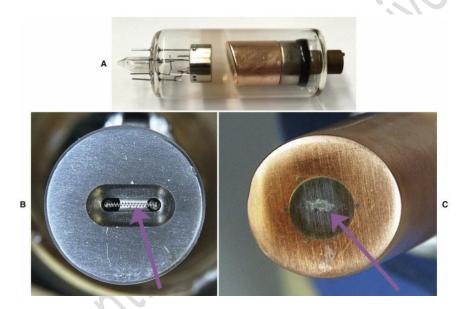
(A) Dental x-ray tube with cathode on left and copper anode on right. (B) Focusing cup containing a filament *(arrow)* in the cathode. (C) Copper anode with tungsten inset.
